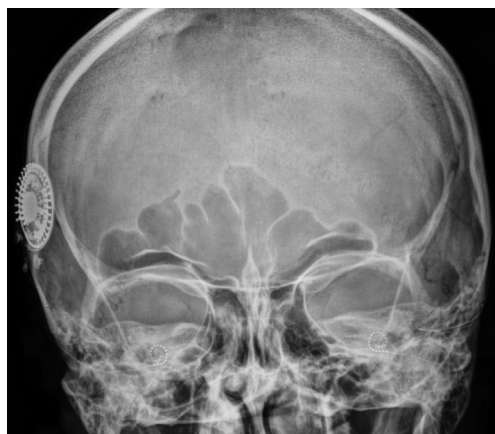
Skull radiography showing the placement of receptor-stimulator of the cochlear implant (under musculo-cutaneous flap on the right temporal bone) and bilateral cochlear portelectrode insertion for a binaural cochlear implant.
